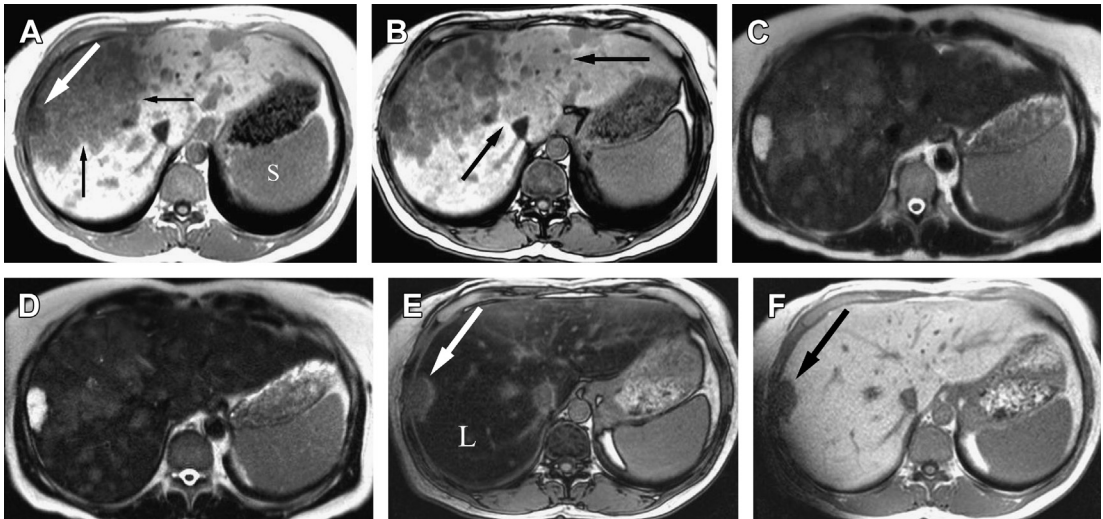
Magnetic resonance demonstration of hepatic hemangioma and metastatic breast cancer in a 51-year-old woman. Metastases, cysts, and hemangiomas are almost all hypointense relative to liver on T1-weighted images. (A) Axial in-phase T1-weighted image shows low signal intensity hemangioma (*white arrow*) and infiltrative multifocal metastases (*smaller black arrows*). The metastases are isointense and the hemangioma is hypointense to spleen (S). However, the authors prefer to use T2-weighted images, diffusion-weighted images, and/or enhanced imaging to differentiate solid masses, such as metastatic disease, from nonsolid hepatic cysts and hemangiomas. (B) Corresponding opposed-phase image shows similar relative signal intensities of the hemangioma and metastatic disease. Geographic regions of lower signal intensity within the left lobe of liver (*black arrows*) represent steatosis. (C, D) T2-weighted fast-spin-echo images obtained with effective echo times of 90 (C) and 180 ms (D). The hemangioma is hyperintense to spleen, whereas the metastases are isointense. As the echo time increases, the contrast between the hemangioma and the adjacent metastases improve. This improvement is not because the hemangioma lights up or enhances; rather, the improved image contrast is because the hemangioma loses less signal as the echo time increases compared with liver, spleen, and metastases. (E) Opposed-phase T1-weighted imaging performed 2 years prior shows that the hemangioma (*arrow*) is hyperintense to the surrounding liver (L). When trying to establish the hepatocellular origin of a focal liver lesion by showing isointensity or hyperintensity to liver, one should use an in-phase image as steatotic liver can be of low signal intensity on opposed-phase imaging and can confound relative signal assessment. (F) Corresponding in-phase T1-weighted image shows that the hemangioma (*black arrow*) is hypointense to the steatotic liver.
